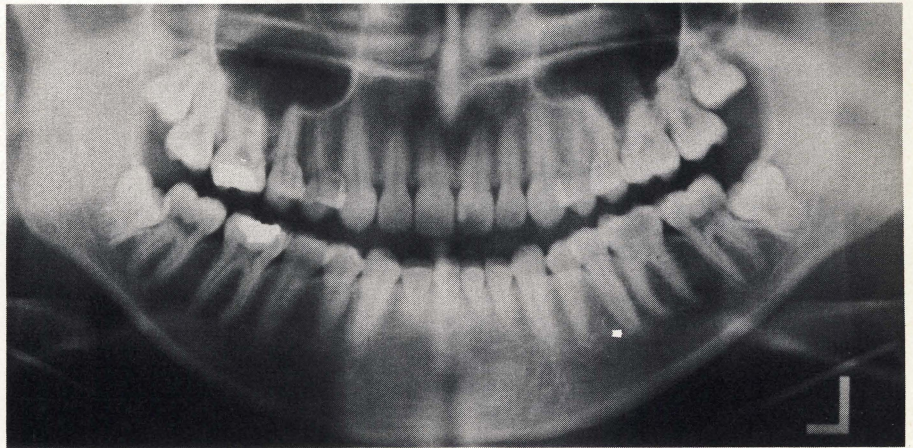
Panoramic radiograph of patient at initial visit.
